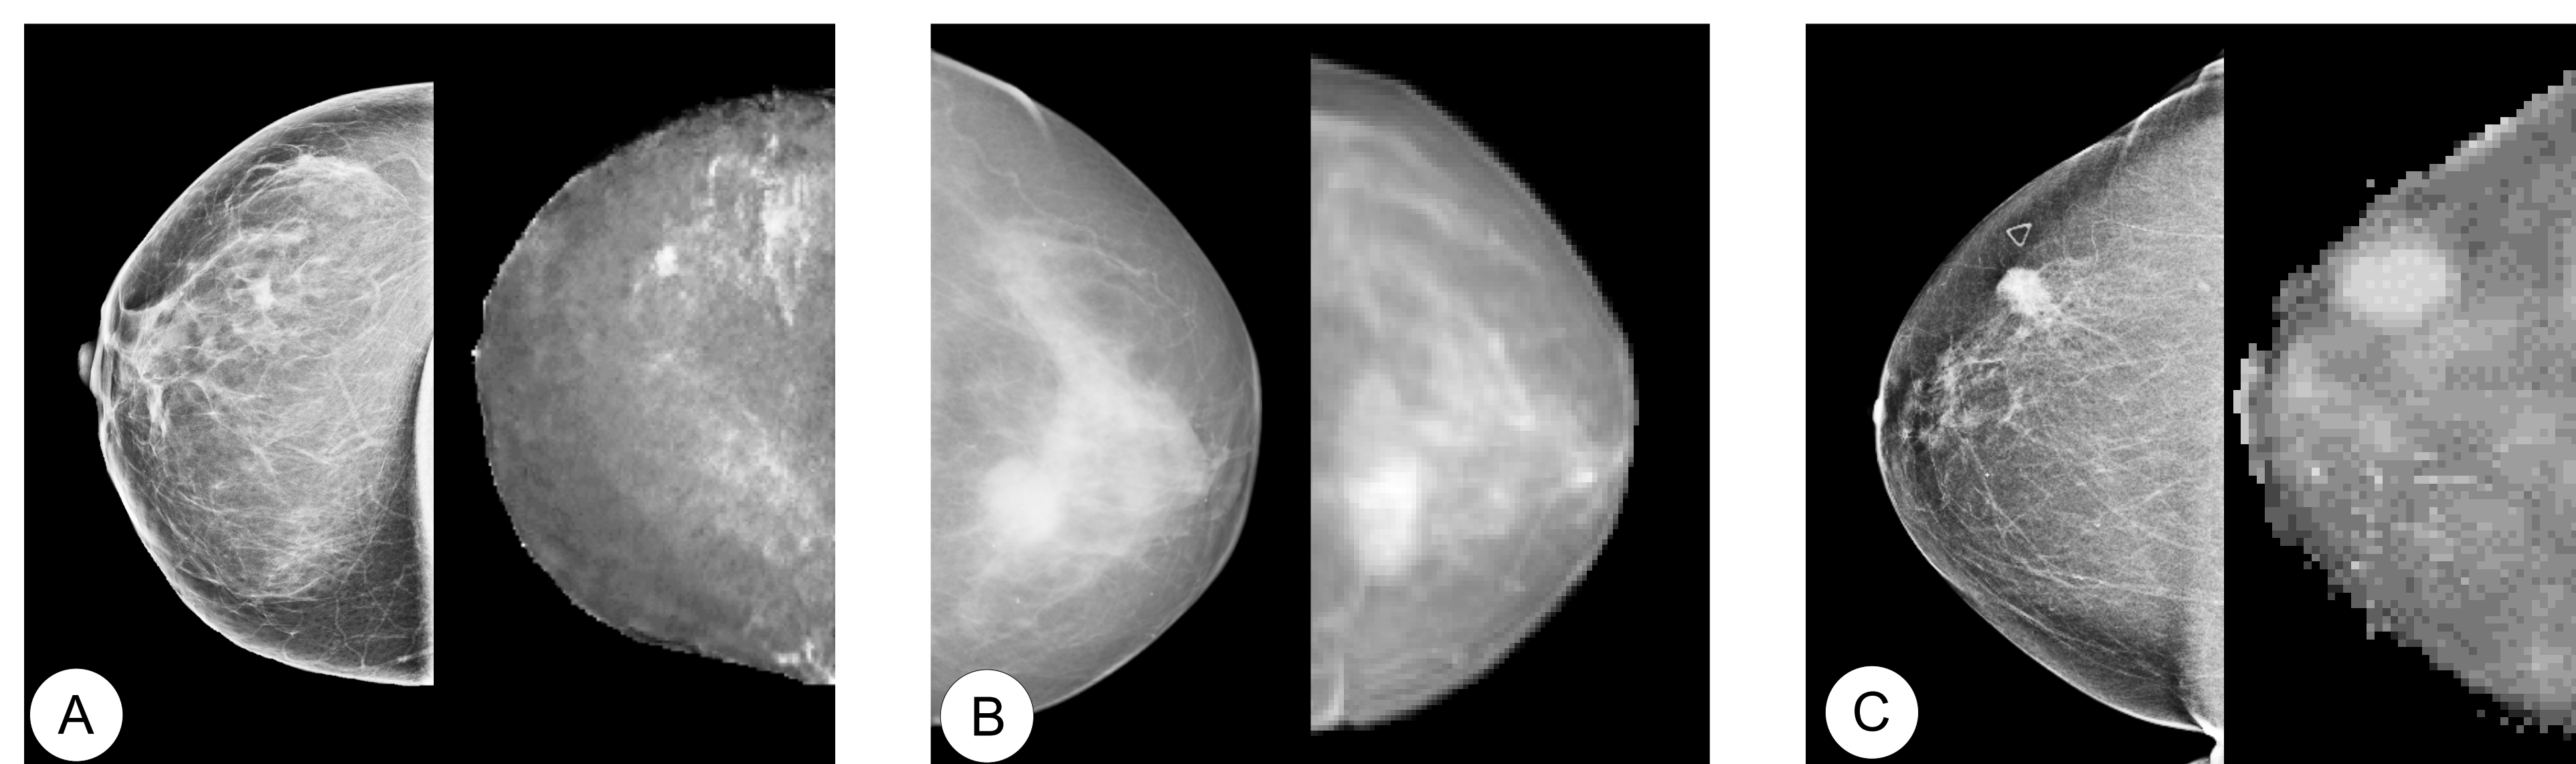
Registration results with three different modalities: X-ray mammogram (left) and projection image of the registered volume image (right) acquired by (A) 1.5T MRI, (B) 3T MRI, (C) USCT.
